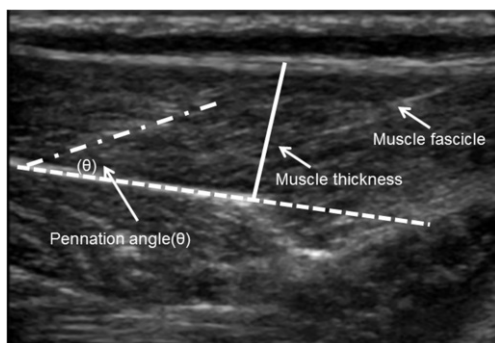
Ultrasound image showing measurements of muscle structure.
